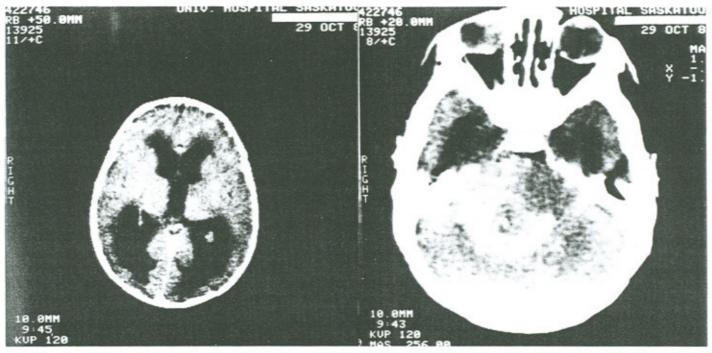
(a and b) Selected cuts of a plain and contrast-enhanced CT scan of the head. (a) The plain CT shows enlargement of the posterior aspects of the lateral ventricles, indicating obstructive hydrocephalus. (b) With contrast, a cut through the posterior fossa demonstrates a radiodensity slightly to the right of midline, consistent with an infiltrating primary neoplasm of the cerebellum.
